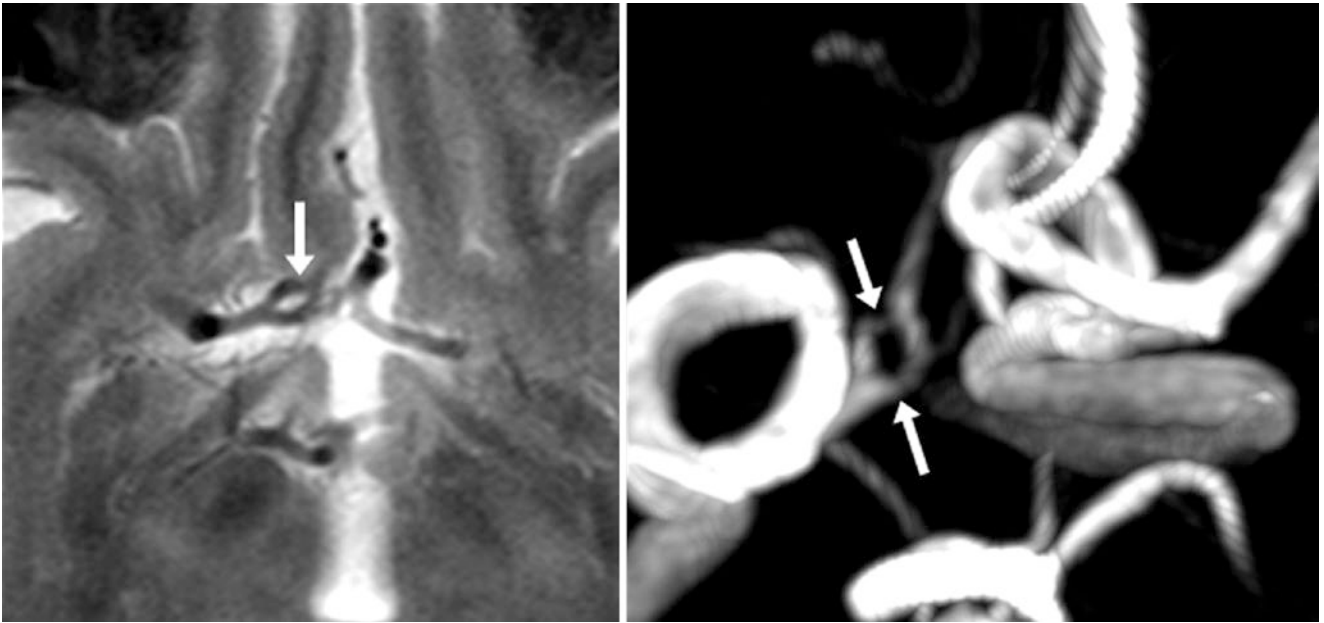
29-year-old with a right ACA A1 segment fenestration (*between arrows*) on axial T2WI MRI (*left*), and 3DTOF MRA superior oblique view (*right*)
